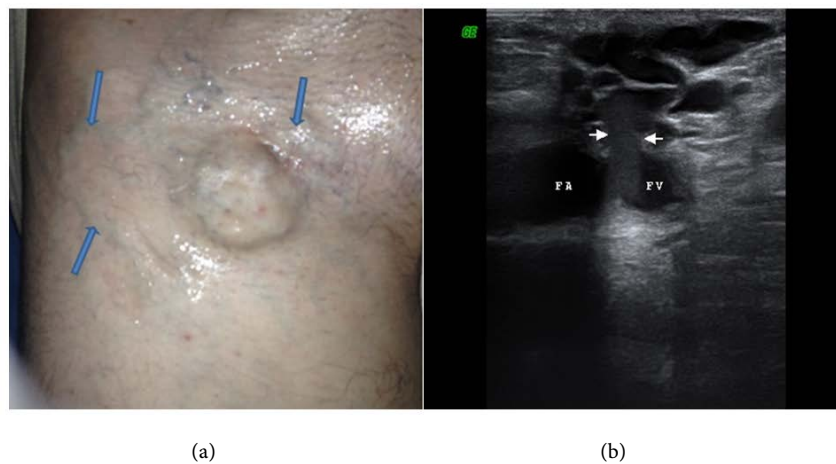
(a) Right inguinal demonstrates focal superficial protrusion, note prominent superficial veins at the periphery of the main lesion (arrows), (b) B-mode ultrasound image from focal inguinal bulging demonstrates injection site (between arrows) connected femoral vein and varicose packets, FA (femoral artery), FV (femoral vein).
